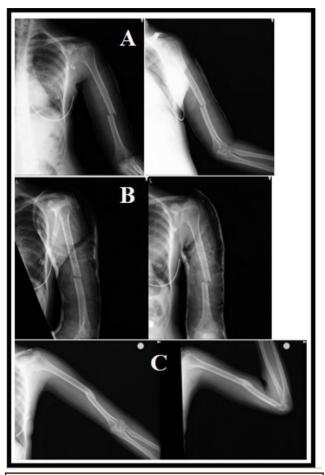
Outpatient control radiographies (A: inital radiographies, B: first month radiographies, C: first year radiographies)
